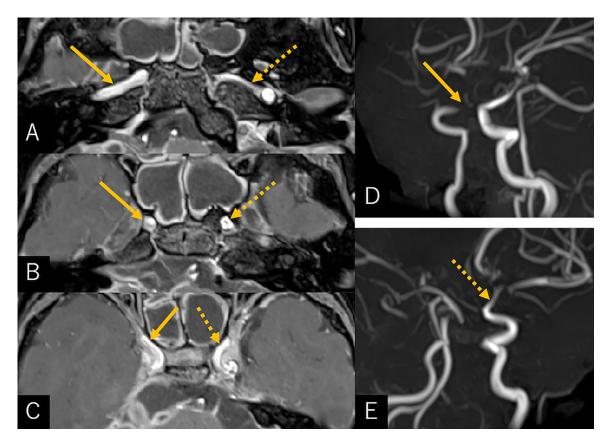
(A-C) Postcontrast axial T1-weighted magnetic resonance images at the levels of the petrous (A), cavernous (B), and paraclinoid (C) segments of the internal carotid arteries, performed at the second presentation, showing evident stenosis in the paraclinoid segment of the right internal carotid (C, arrow). (D, E) Gerebral magnetic resonance angiography, oblique views, showing tapered flow of the right paraclinoid ICA (D, arrow). Arrow: right internal carotid artery; dashed arrow: left internal carotid artery.
